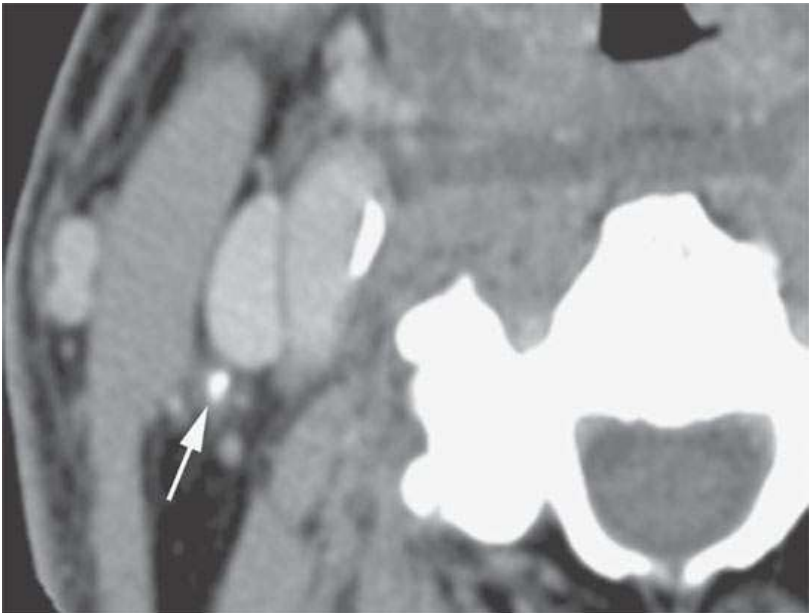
Computed tomography of surgically proven dystrophic calcification in a metastatic cervical lymph node containing residual cancer following radiotherapy.
